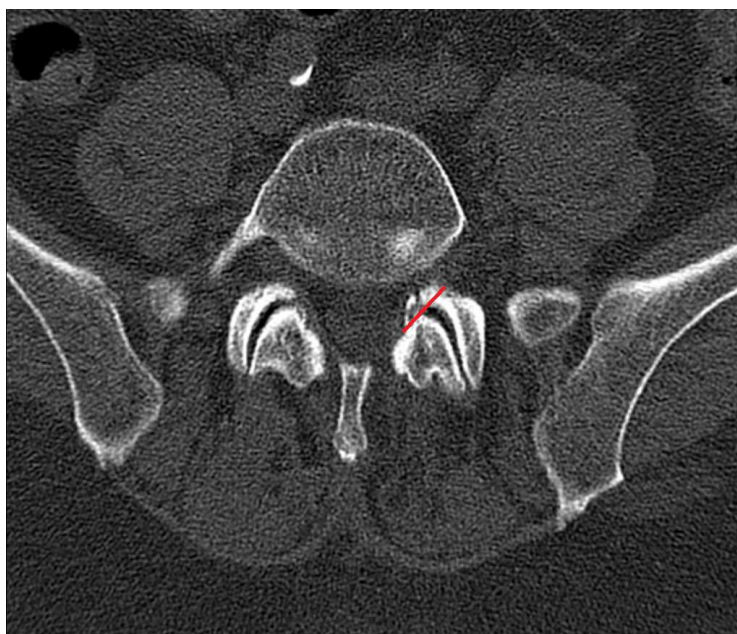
Preoperative CT of patient no. 1 showing the foraminal stenosis making the percutaneous approach impossible, the degree of foraminotomy performed is given by
